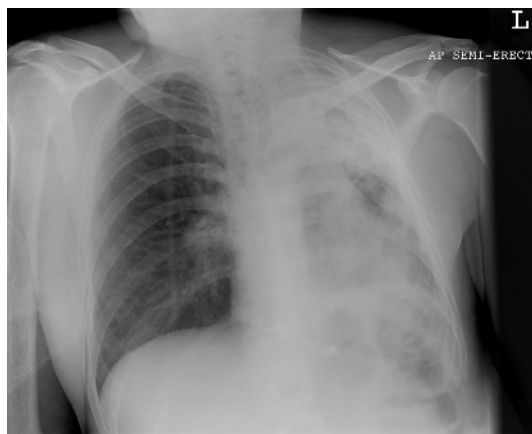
Chest radiograph showing left apical consolidation, volume loss and pleural thickening.
